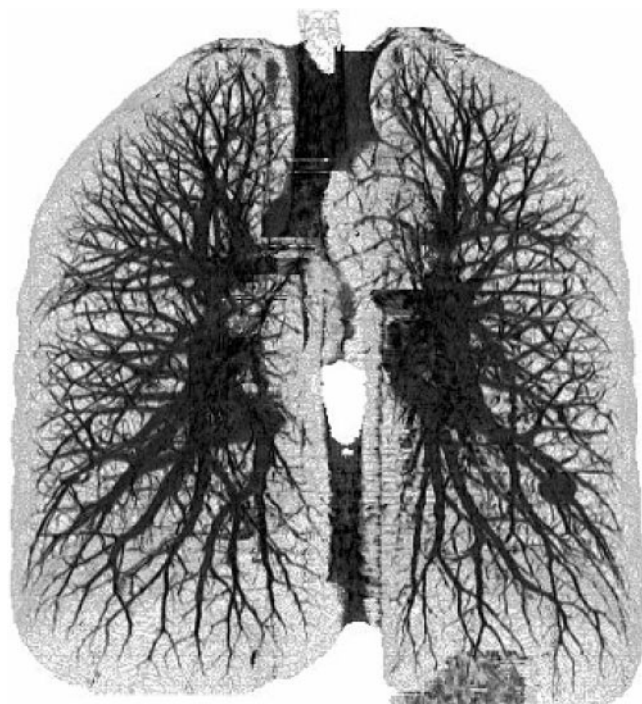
Vessels and airways of the lung, visualised after automated segmentation of a high resolution CT data set (1 mm slice thickness, 400 slices, inverted maximum intensity projection).
